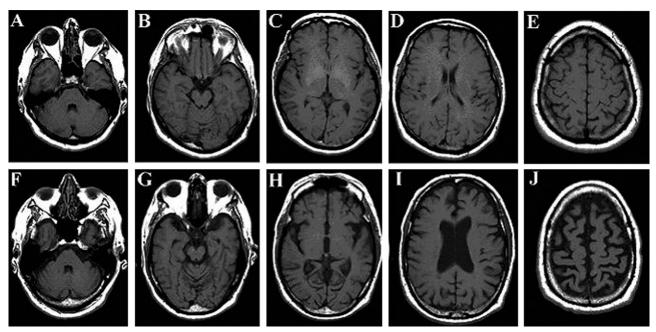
Widespread brain atrophy in multiple sclerosis (MS). Comparison of noncontrast T1-weighted spin-echo axial MRI scans of a healthy control in the fifth decade (A–E) versus an age-matched patient with secondary-progressive MS (F–J). The patient with MS has moderate physical disability (Expanded Disability Status Scale score of 6) and a disease duration of 12 years. Note widespread supratentorial and infratentorial brain atrophy in the patient with MS (enlargement of the subarachnoid and ventricular CSF spaces including the cortical sulci, Sylvian fissures, basal cisterns, lateral ventricles, and third and lateral ventricles compared to the healthy control).
